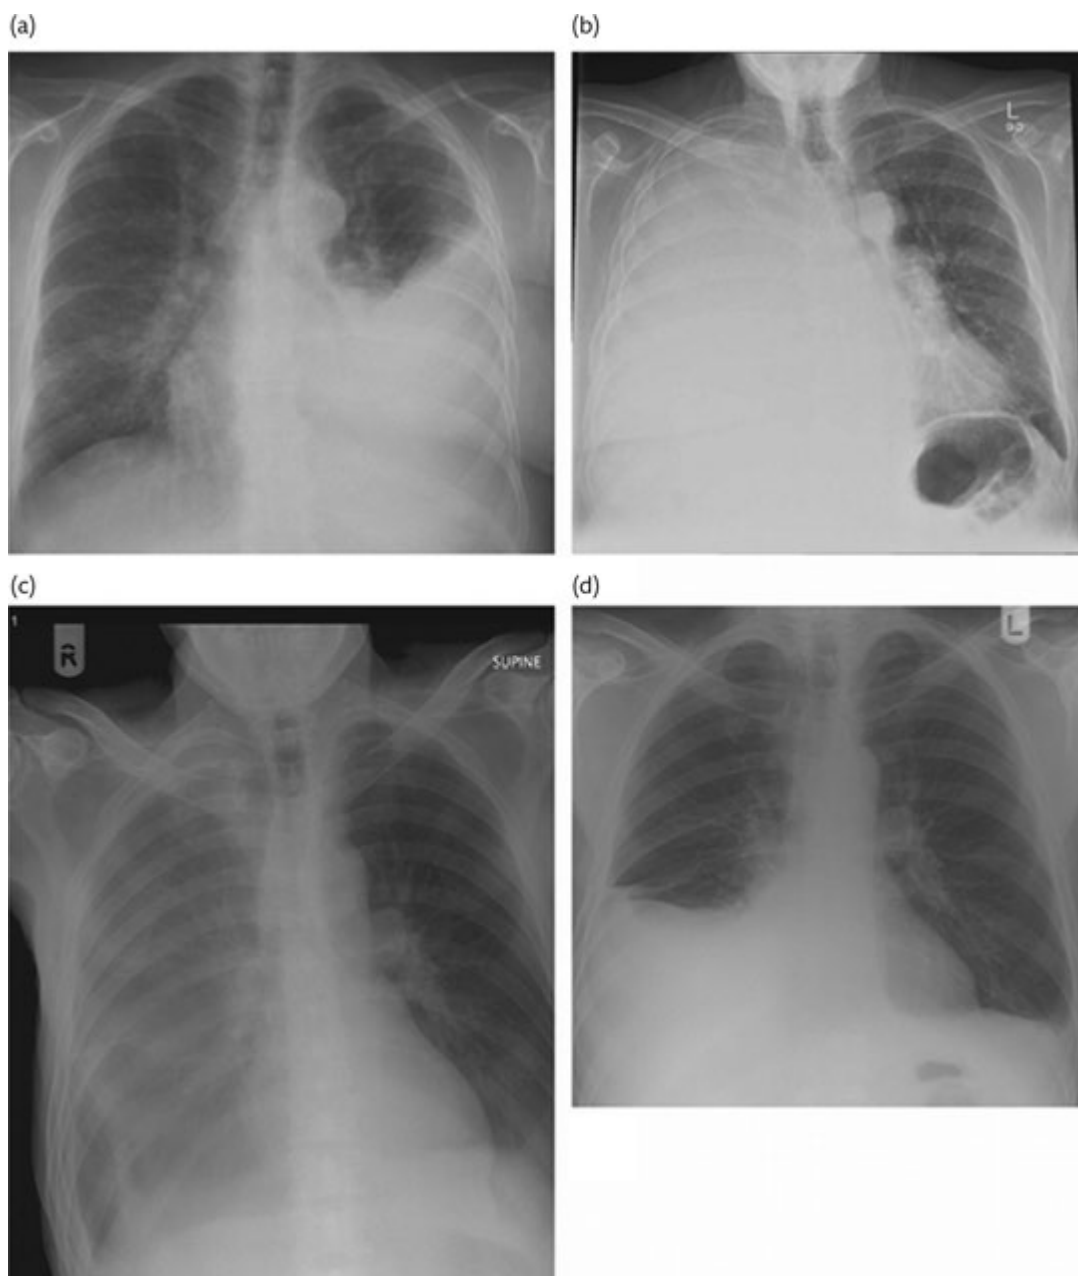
Chest radiograph appearances of a free-flowing left pleural effusion imaged erect (a); a massive right pleural effusion with mediastinal shift (b); and a pleural effusion radiographed supine (c) and erect (d) in the same patient.
